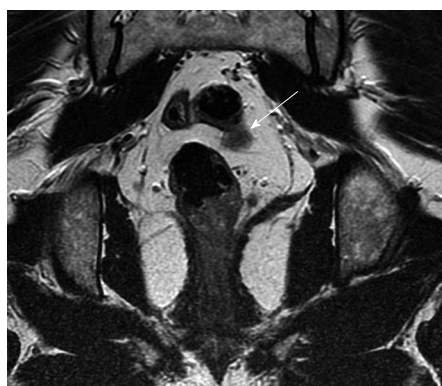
Coronal magnetic resonance imaging (arrow) showing possible lymph node or early vascular involvement.
